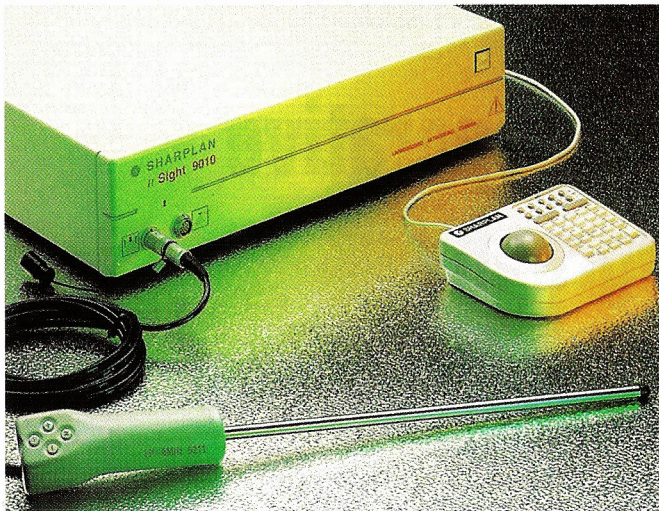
Ultrasound system with 10-mm laparoscopic probe.
